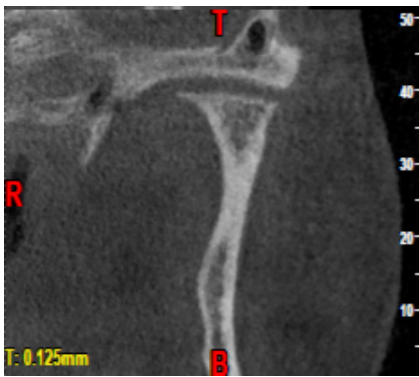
Coronal view of CBCT demonstrating the osteophytic lipping of condyle
